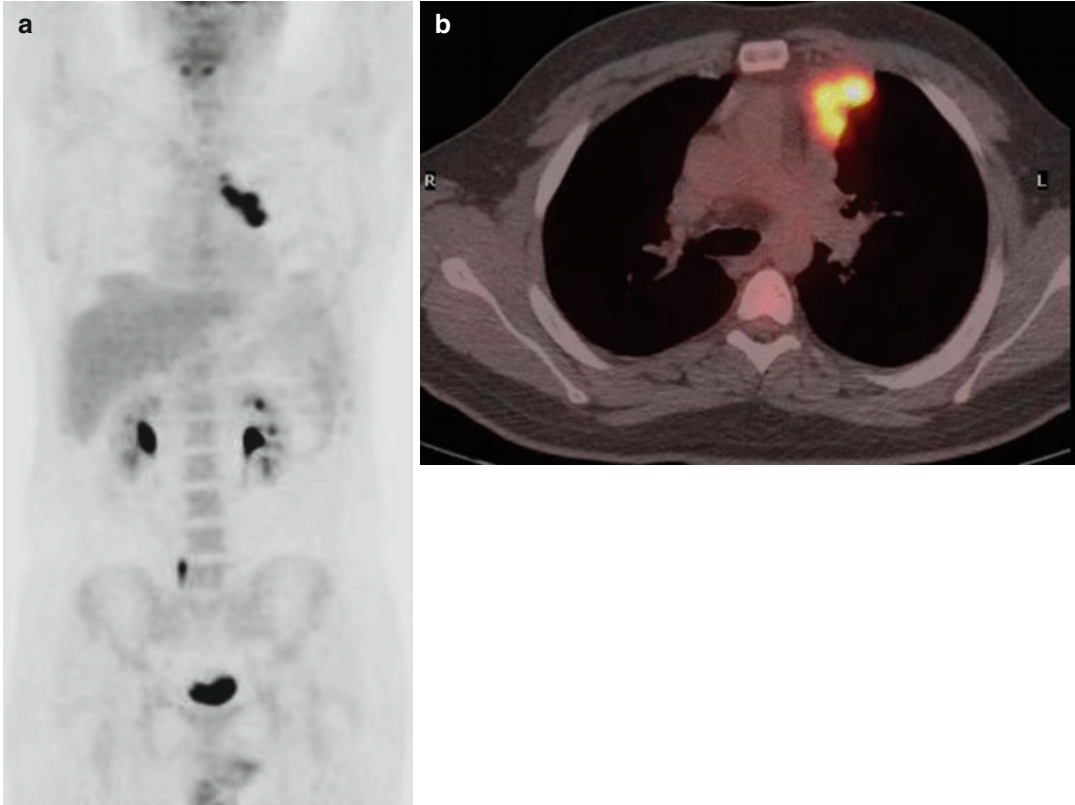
(a, b) MIP-PET and fused PET/CT post immunotherapy: Highly hypermetabolic mediastinal residual mass (SUV_{max} 20; D5-PS score 5)
